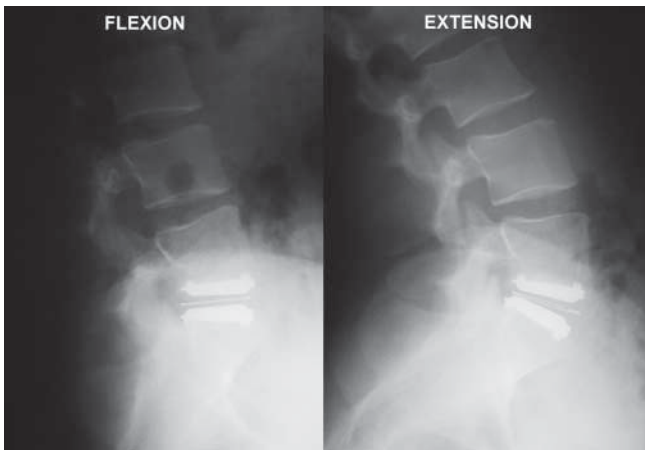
Dynamic radiographs at the 6-year follow-up show segment excursions
